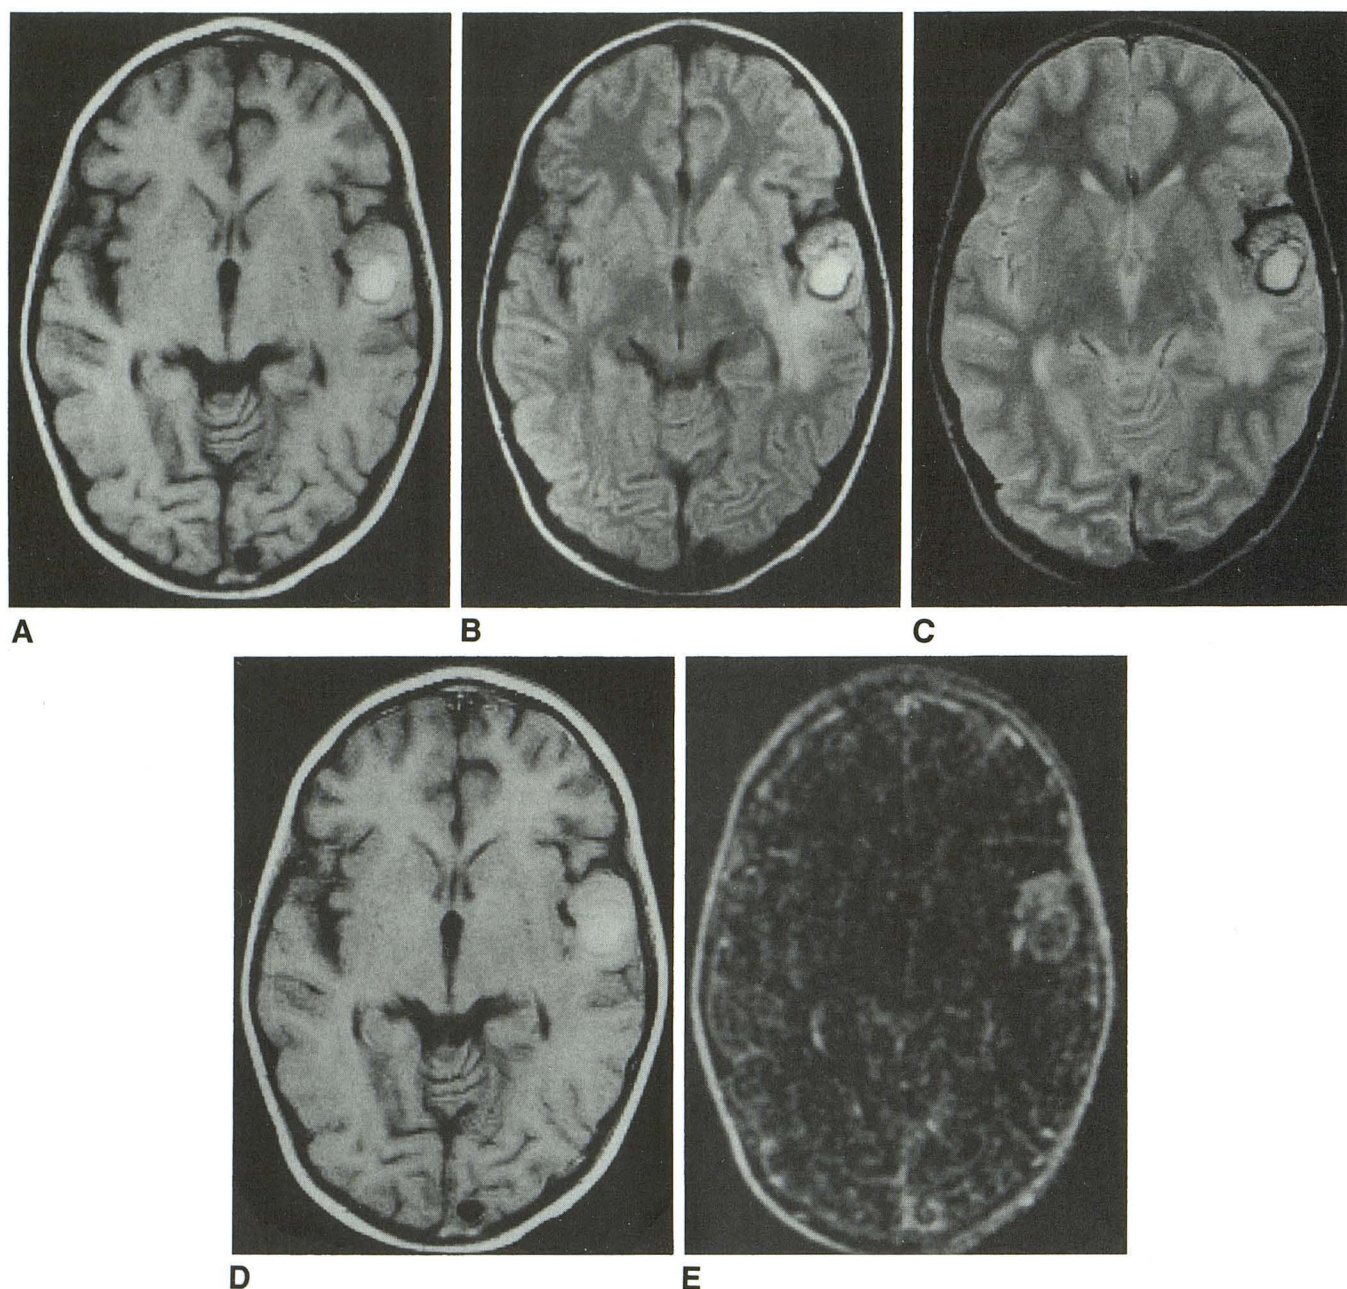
Six-year-old patient with known retroperitoneal neuroblastoma. A–C, Unenhanced transverse T1-weighted (550/15) (A) proton-density-weighted (2500/25) (B), and T2-weighted (2500/90) (C) images obtained at same level show a left temporal lesion consistent with subacute hemorrhage. D, Contrast-enhanced T1-weighted (550/15) image does not clearly show enhancement. E, Subtraction of A from D shows adjacent anterior nodular enhancement, suggesting that tumor caused the hemorrhage.
